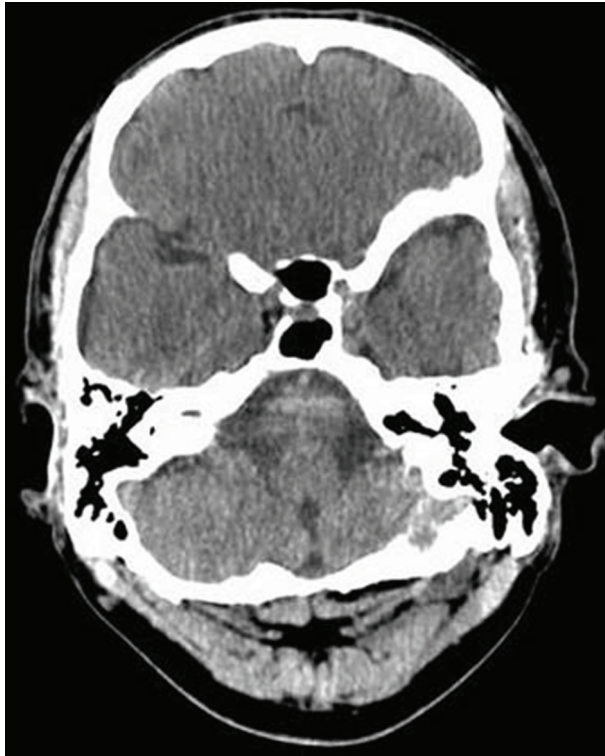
Admission CT – no infarct.
